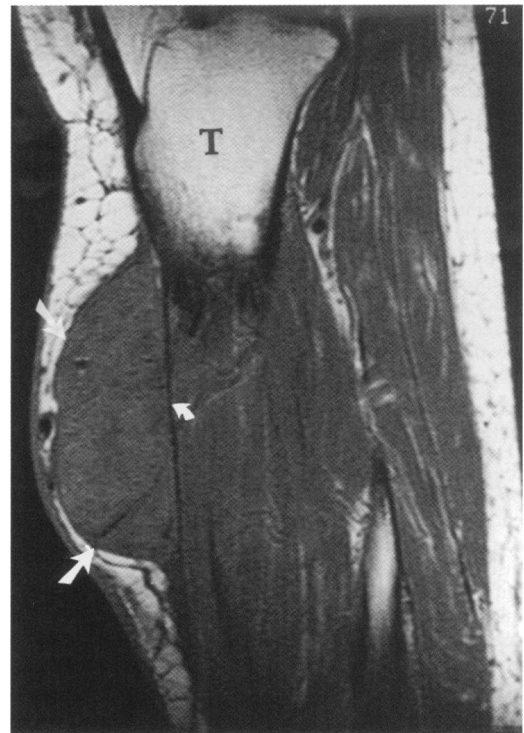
The sagittal T1 weighted magnetic resonance image through the lower leg showing a 6 cm well defined mass (larger white arrow) which is sitting on top of the apparently uninvolved fascia (smaller curved white arrow); T = tibia.
